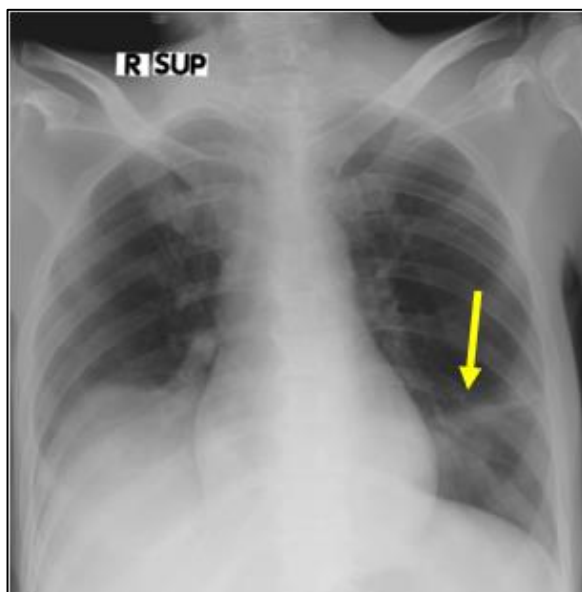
Follow up 2 weeks after treatment, chest X-ray only showed minimal fibrosis in left lung fields (yellow arrow).
